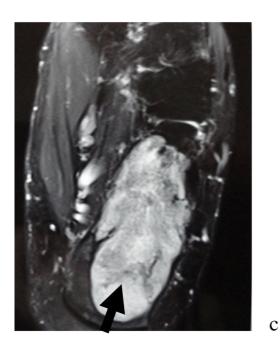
Hemangioma. Axial view of the calcaneus (a) shows an irregular, lytic lesion with prominent reticulated trabecular pattern (arrows) and sclerotic margins. MRI T1W (b) and fat suppressed T2W (c) images show low signal intensity replacement of calcaneal marrow on T1W and extremely high signal intensity in T2W images. There is minimal internal fatty signal change (arrow).
